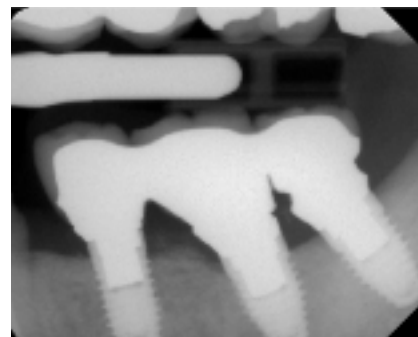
Radiograph of the finished prosthesis. Because of the severe misangulation of the individual implants as well as in relationship to each other, margins couldn't be closed.
